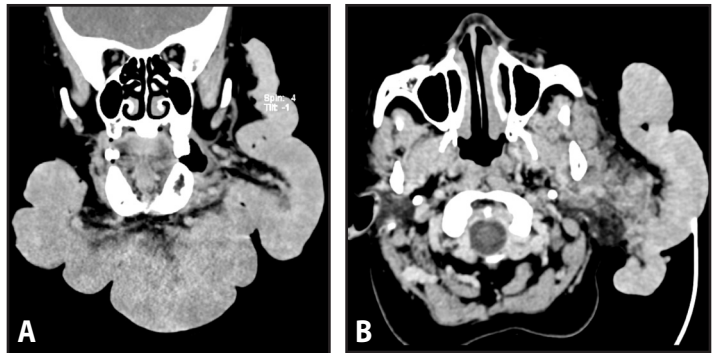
Contrast enhanced computed tomograph: A. Coronal view showing facial mass measuring 21.43 x 9.91 x 20.75cm.; and B. Axial view at the level of the maxillary sinuses, showing extent of the mass to the superficial lobe of the parotid
